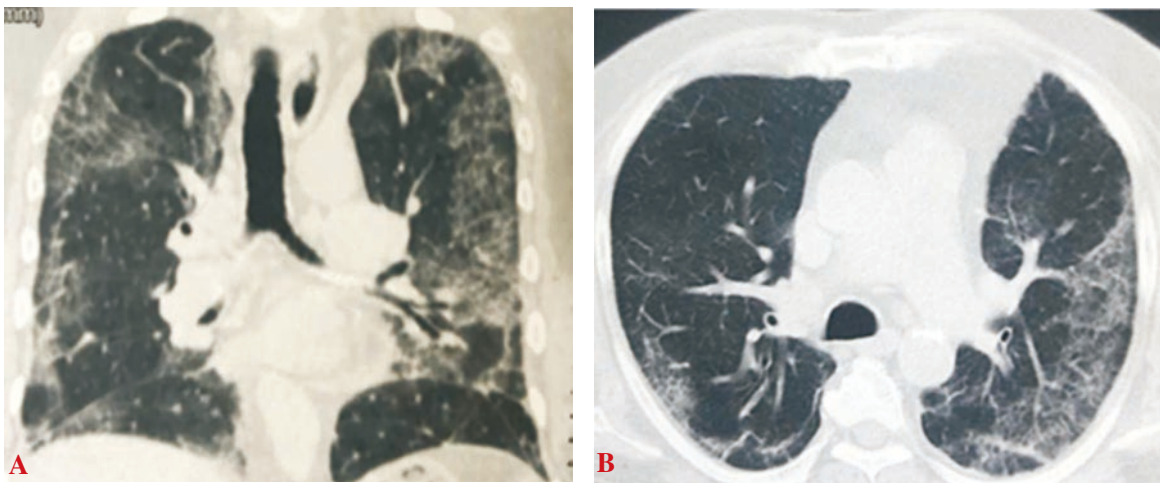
CT scan of a 67-year-old moderate COVID-19 patient showing multifocal ground-glass opacity, crazy paving, and subpleural reticular opacities in bilateral lung fields, involving all lobes, predominantly peripheral subpleural region. A: Coronal section; B: Axial section.
